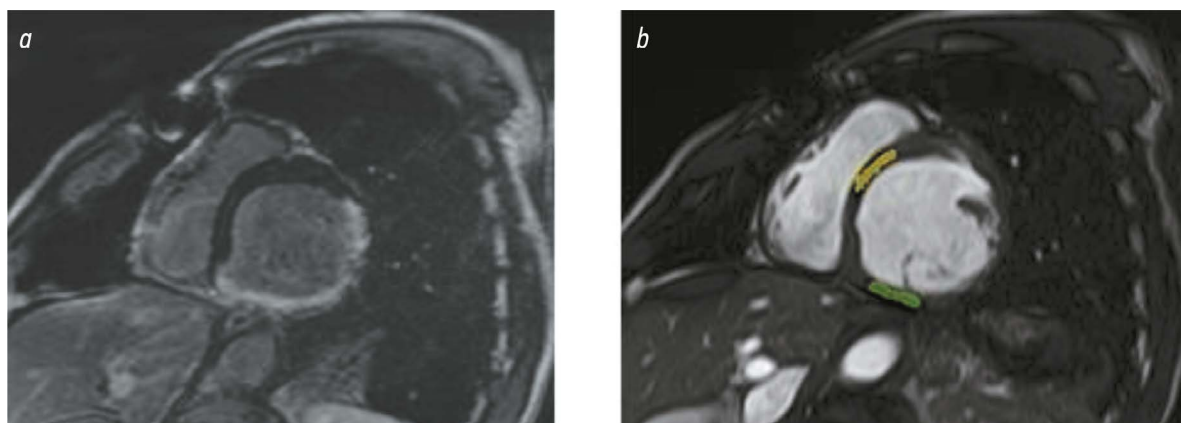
Selection of regions of interest in post-contrast and non-contrast-enhanced cardiac MRI images, short axis view. *a*: time-delayed contrast-enhanced MRI showing transmurular contrast uptake along the LV inferior wall with no signs of damage in the interventricular septum. *b*: cardiac cine-MRI showing regions of interest in the posterior wall (green), corresponding to a PICS area in the inferior segment at the middle LV level, and in the anteroseptal segment at the middle level (yellow), corresponding to an intact interventricular septum.
